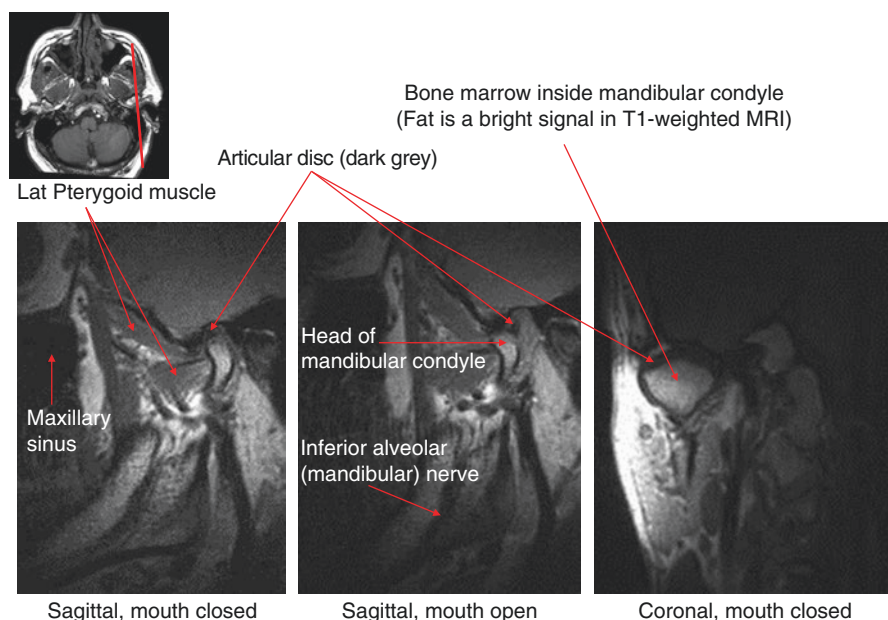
T1-weighted magnetic resonance imaging (MRI) of the TMJ
